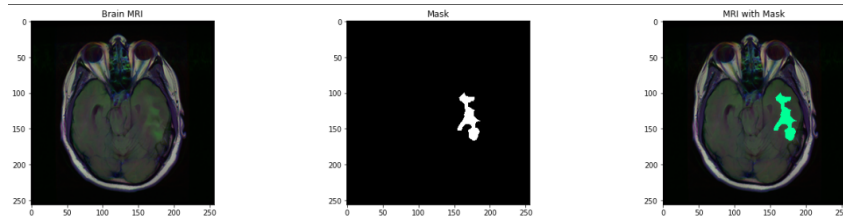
Annotated MRI with lesion mask overlay
